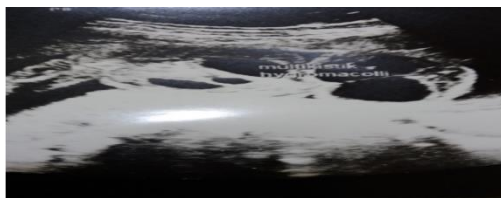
Fetomaternal ultrasound at 14 weeks of gestational age
